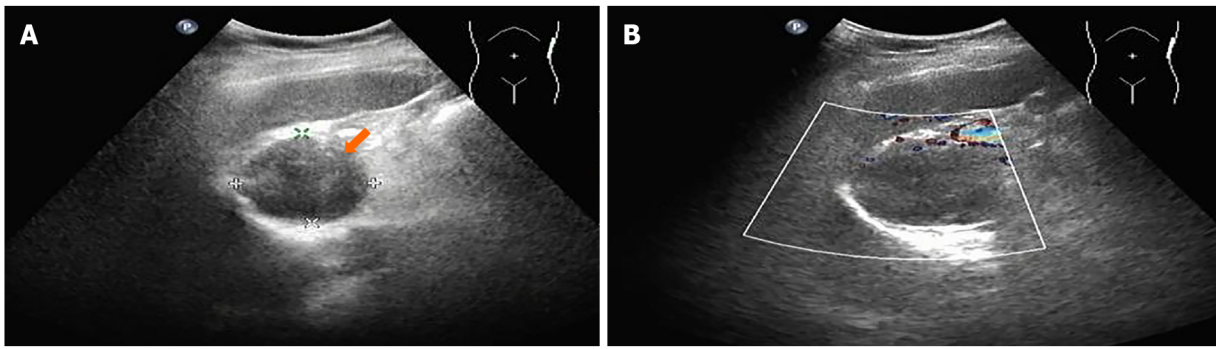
Conventional abdominal ultrasound examination. A: Gray-scale sonography showed a hypoechoic lesion (orange arrow), size 4.7 cm × 4.4 cm, with clear and regular boundary, between the upper pole of the spleen and the abdominal aorta; B: Color Doppler showed no evident blood flow.
